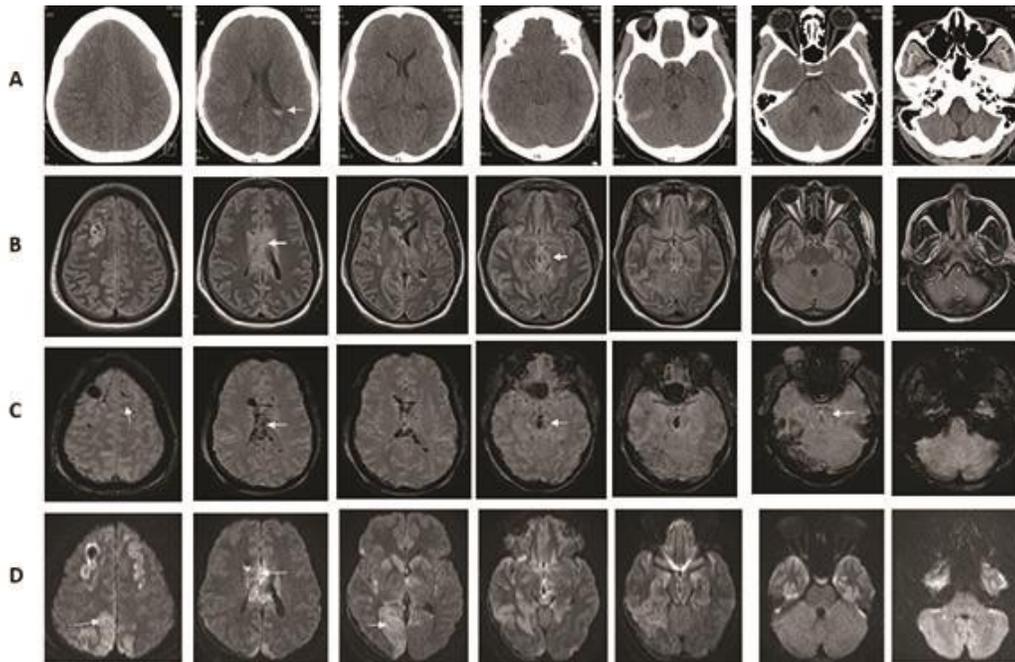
Computed tomography (CT) of head at admission and magnetic resonance imaging (MRI) on day 5 of injury. Row A: Computed tomography views indicating evidence of intraventricular bleed (arrow). Row B: Fluid Attenuation Inversion Recovery (FLAIR) MRI views of brain indicating hyperintense subcortical, corpus callosum, central core and brainstem (mainly mesencephalon) injuries (arrows). Row C: Susceptibility Weighted Images (SWI) of brain indicating hemorrhagic subcortical, corpus callosum, central core, mesencephalon and pontine injuries. Row D: Diffusion weighted Images (DWI) views of brain indicating restricted diffusion in parasagittal and occipital cortices, central gray, corpus callosum and midbrain (arrows), (Courtesy of Bizhan Aarabi, University of Maryland).
